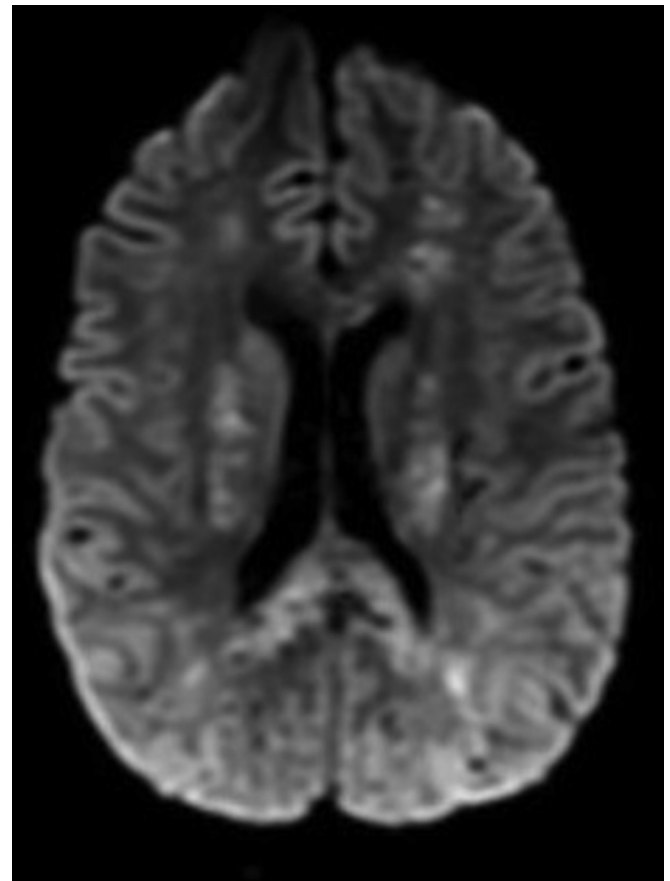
MRI-DWI axial image of a 17-year-old adolescent diagnosed with SCD, hospitalised due to respiratory distress, showing the typical “starfield pattern” of cerebral fat embolism syndrome with bilateral tiny DWI hyperintense foci within the white matter and grey matter, with some bias towards the watershed regions.
